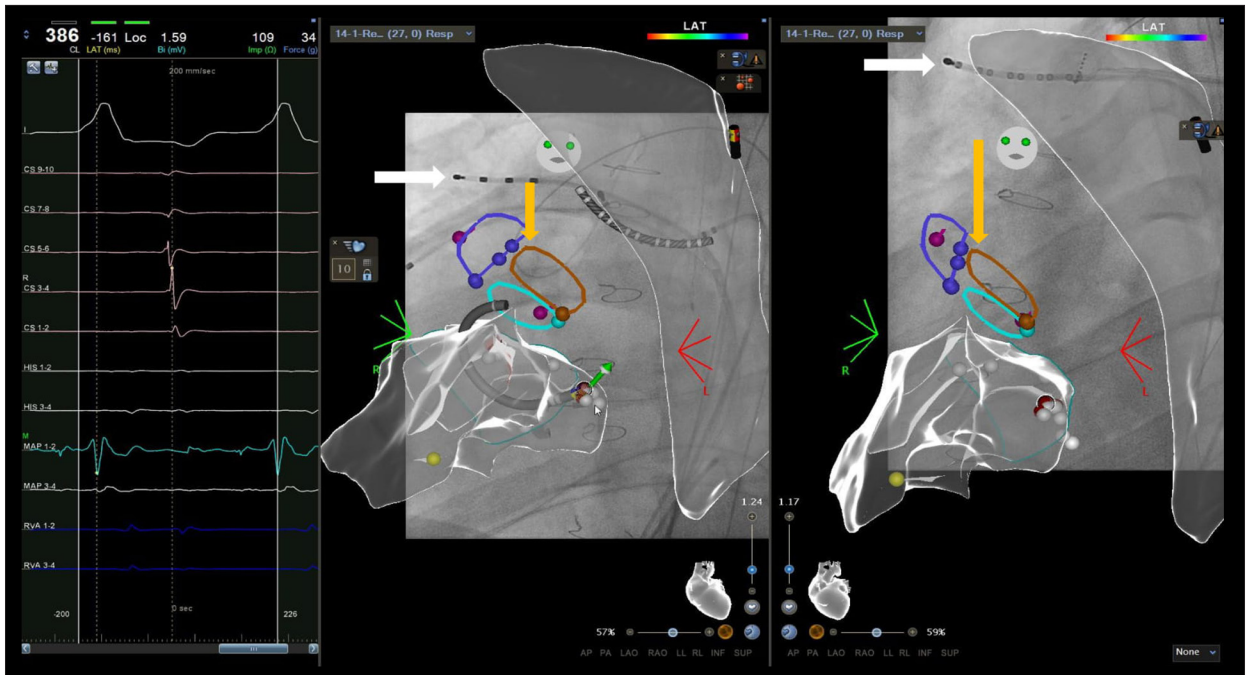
Intracardiac echocardiography and CARTO advanced 3-dimensional cardiac mapping showing catheter advancement (white arrow) and 3 cusps of the aortic valve (yellow arrow).
